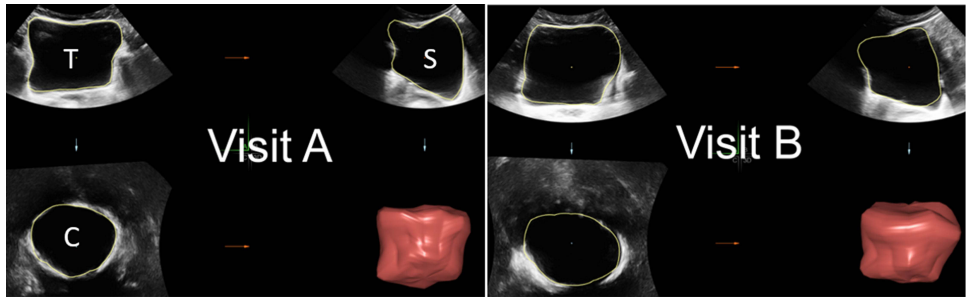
Example of 3-D ultrasound images and rendered models of a bladder at similar volumes ((A) 299.2mL, (B) 308.2mL) from two visits one week apart. Abbreviations: T, transverse plane; S, sagittal plane; C, coronal plane.
